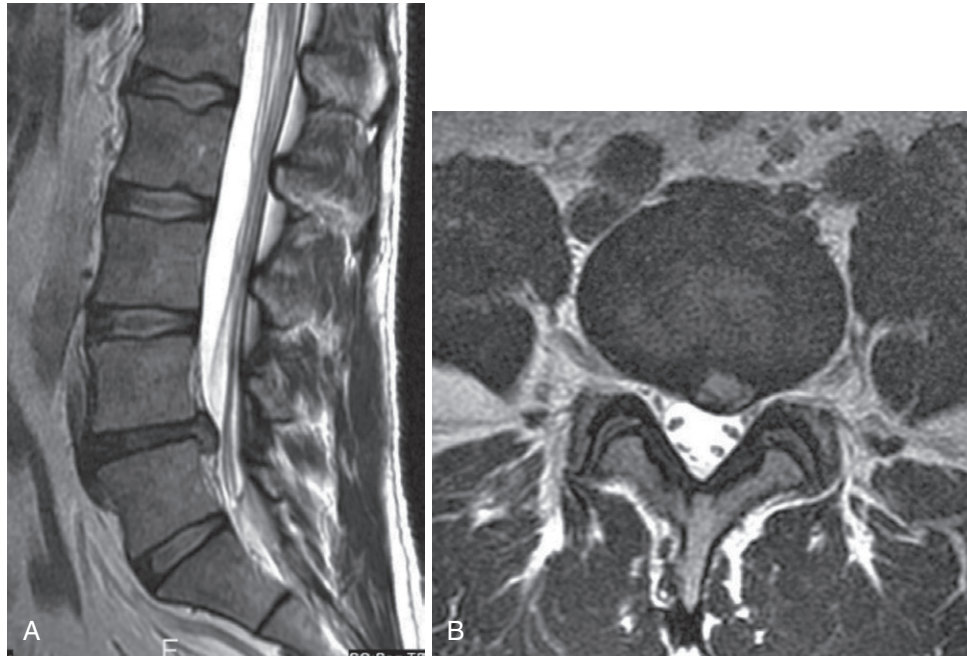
Lumbar disk extrusion. A, The sagittal T2-weighted magnetic resonance image shows an extruded disk at the L4-5 level. B, The axial image through the L4-5 level shows disk extrusion to the left side of the neural canal and compressing the exiting L5 nerve root against the left lamina. (Courtesy Dr. John Crues, University of California, San Diego.)
